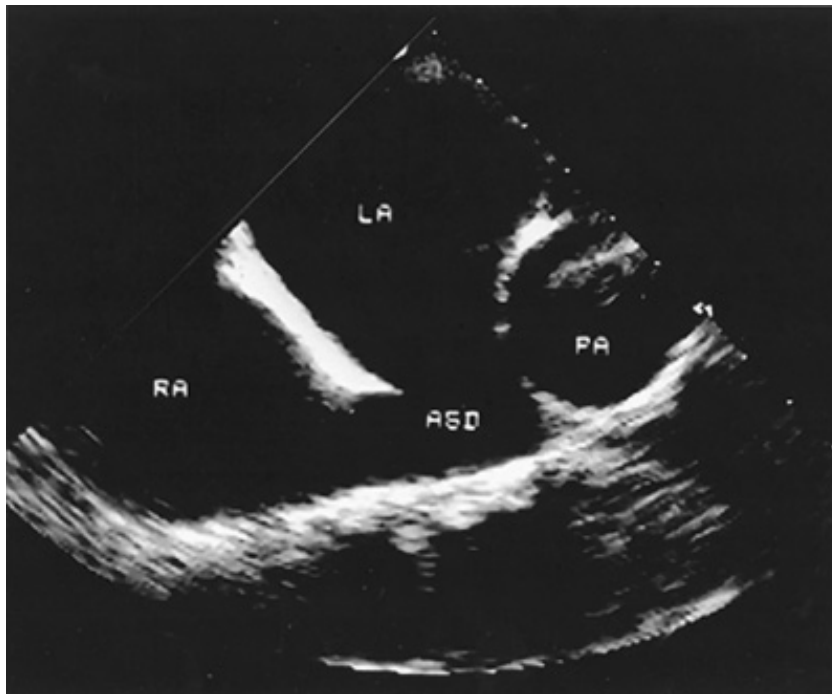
Transesophageal image of a sinus venosus atrial septal defect (ASD) (longitudinal plane). The defect is present in the superior portion of the interatrial septum. RA = right atrium; LA = left atrium; ASD = atrial septal defect; PA = pulmonary artery.
